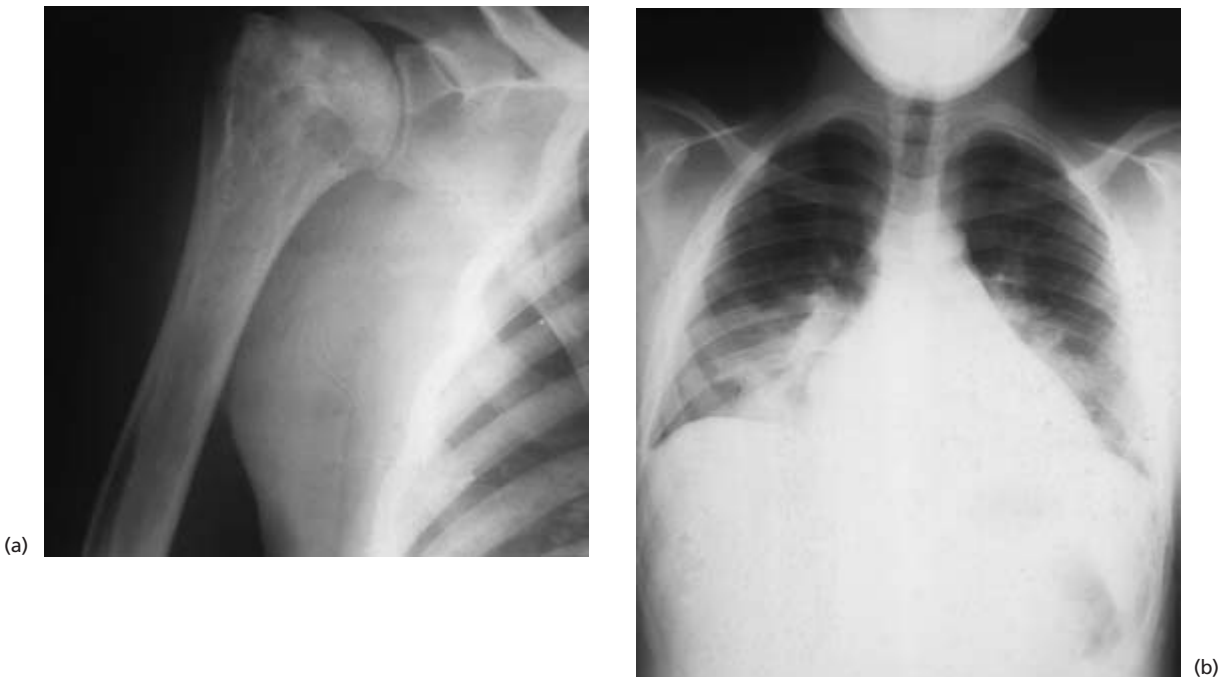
(a) Radiograph of the head of the humerus showing areas of reduced radiodensity consequent on previous infarction. (By courtesy of Professor I. Roberts.) (b) Chest radiograph showing opacities in the lower half of both lung fields representing pulmonary infarction as a result of sickle cell formation and vascular occlusion. (By courtesy of Professor I. Roberts.)
